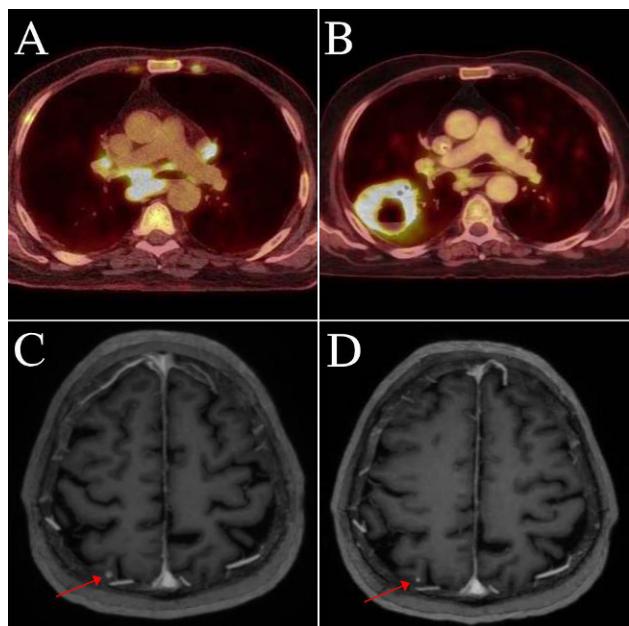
F12 A und B (FDG-PET bei Diagnosestellung des Hodgkin-Lymphoms und 4 Monate später): Entwicklung einer pulmonalen Kaverne mit entzündlichen Begleitläsionen nach onkologischer Therapieeinleitung. C und D (kraiales MRT bei Diagnosestellung der Nokardiose und 4 Wochen später): Regredienz einer zerebralen Läsion nach antiinfektiöser Therapieeinleitung
